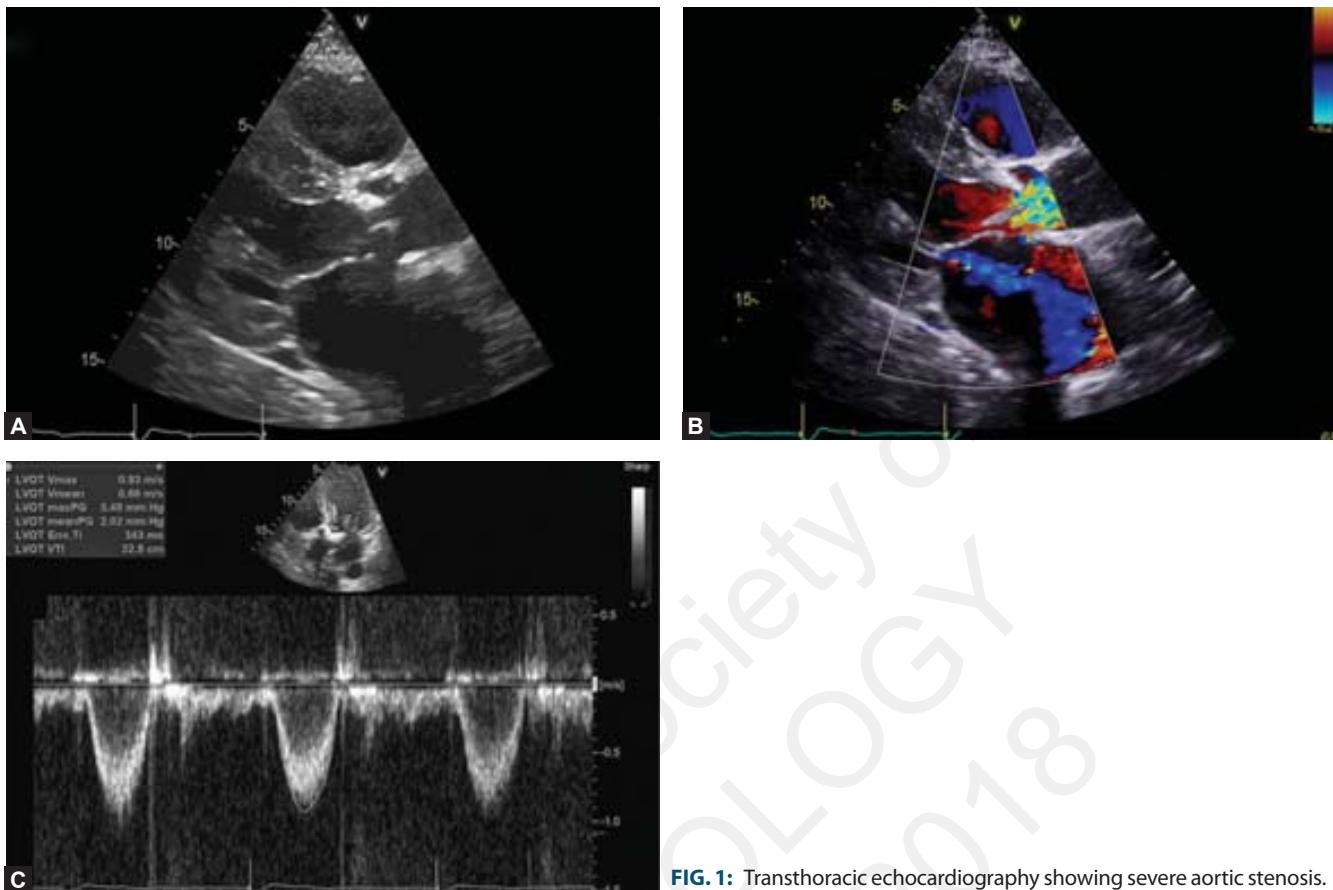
Transthoracic echocardiography showing severe aortic stenosis.
